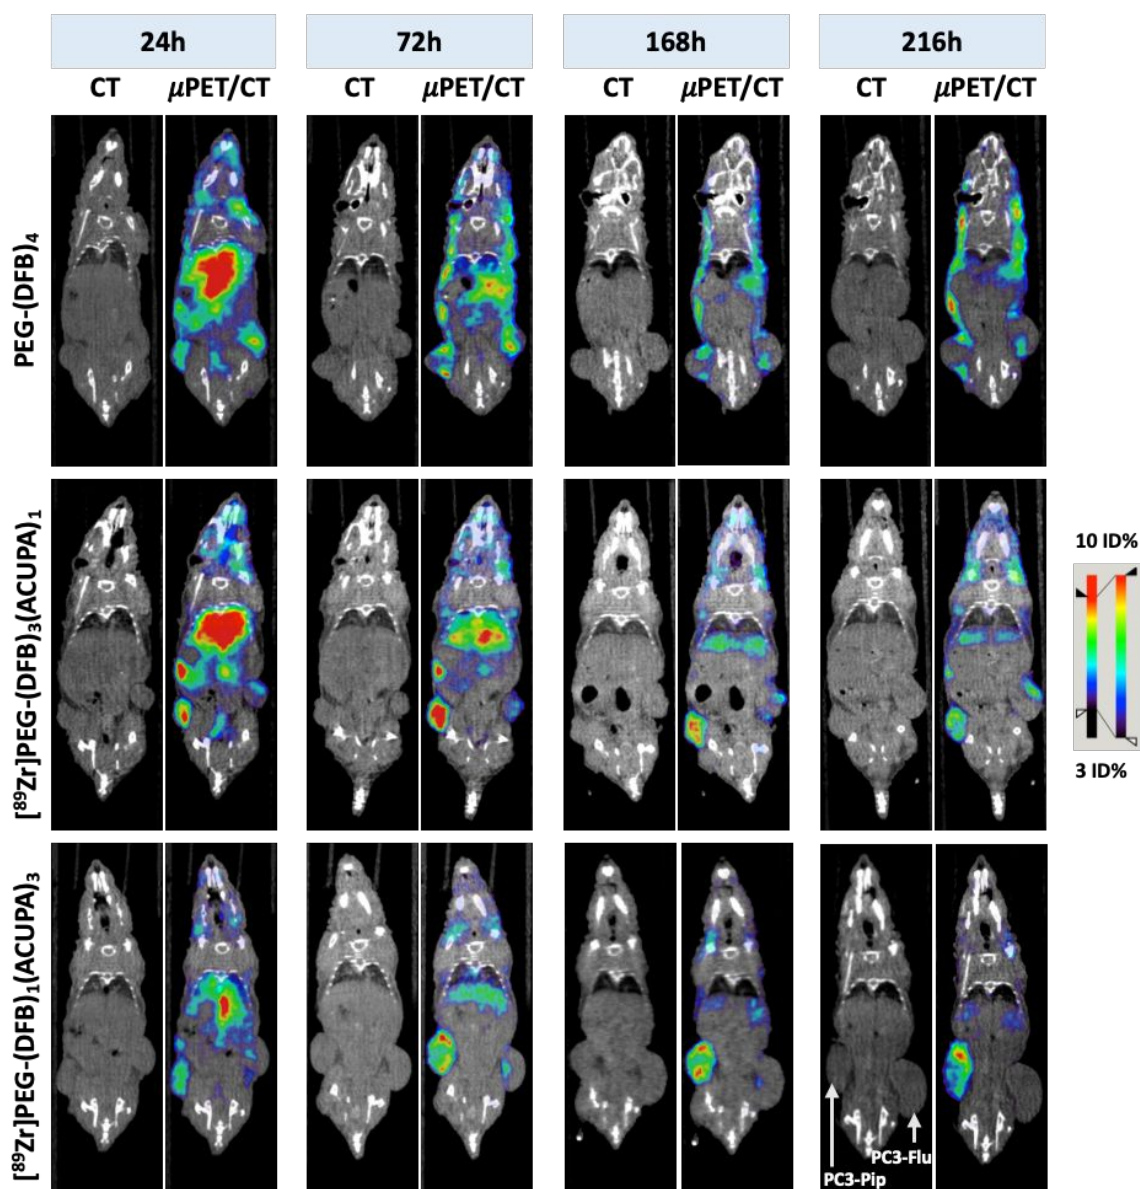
Coronal CT, and coronal μ PET/CT fusion images obtained at 24 h, 72 h, 168 h, and 216 h following administration of ^{89}Zr labeled nanocarriers reveal high tumor uptake with low background tissue retention of [^{89}Zr]PEG-(DFB)₁(ACUPA)₃ over time.
